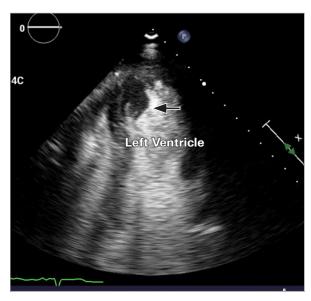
Initial apical 2-chamber transthoracic echocardiogram with an ultrasound-enhancing agent shows a thrombus measuring 2.7×1.3 cm (arrow) within the apex of the left ventricle. Not visualized is an additional 1.25×0.85 cm thrombus and the pseudoaneurysm measuring 8.7×7.6 cm.
